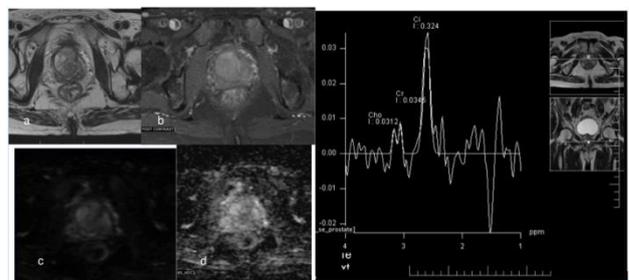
MRI of prostate in benign prostatic hypertrophy; (a): Axial T2WI showing hyperintense lesion involving prostate (b): Post contrast T1WI axial image showing enhancement (c) & (d): Axial DWI showing no restriction and ADC was high (e): MRS showing normal citrate and low Choline values.
